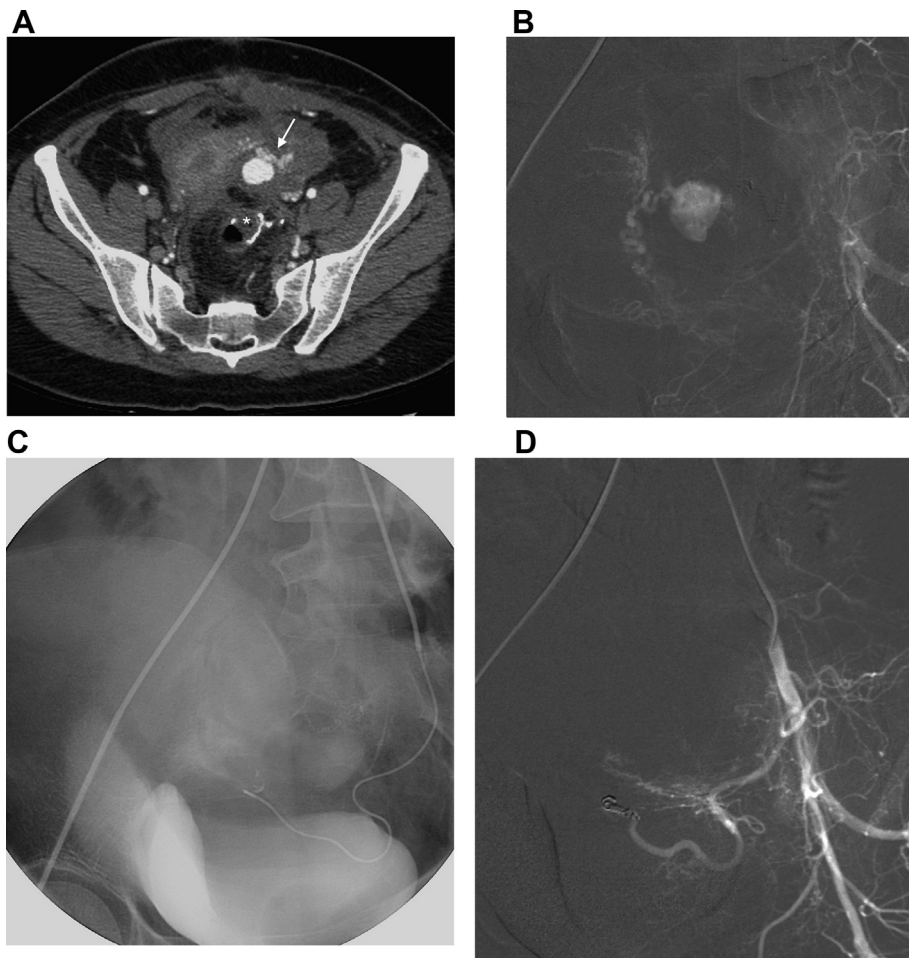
A 34-year old woman with hemorrhagic shock after pelvic surgery for endometriosis. (A) Contrast-enhanced computed tomography shows a pseudoaneurysm close to the left aspect of the uterus (arrow: enlarged left uterine artery; asterisk: circular stapling of sigmoid resection). (B) Digital subtraction angiography of the left internal iliac artery (left anterior oblique view, late phase) confirms the diagnosis of extrauterine pseudoaneurysm supplied by the left uterine artery. (C) Native X-ray direct image of the pelvis after manual superselective arteriography: intraperitoneal diffusion of the contrast medium without evidence of the pseudoaneurysm. (D) Postembolization digital subtraction angiography shows the persistent occlusion of the pseudoaneurysm.
